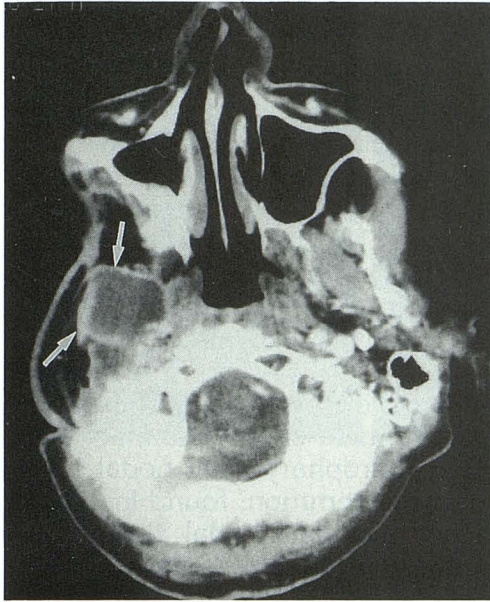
Contrast-enhanced CT reveals focal necrotic recurrence (white arrows) beneath a pectoralis major myocutaneous flap. Notice the cystic appearance with peripheral enhancement. The muscular portion of the flap has atrophied, leaving primarily fat, which is normal in density.
